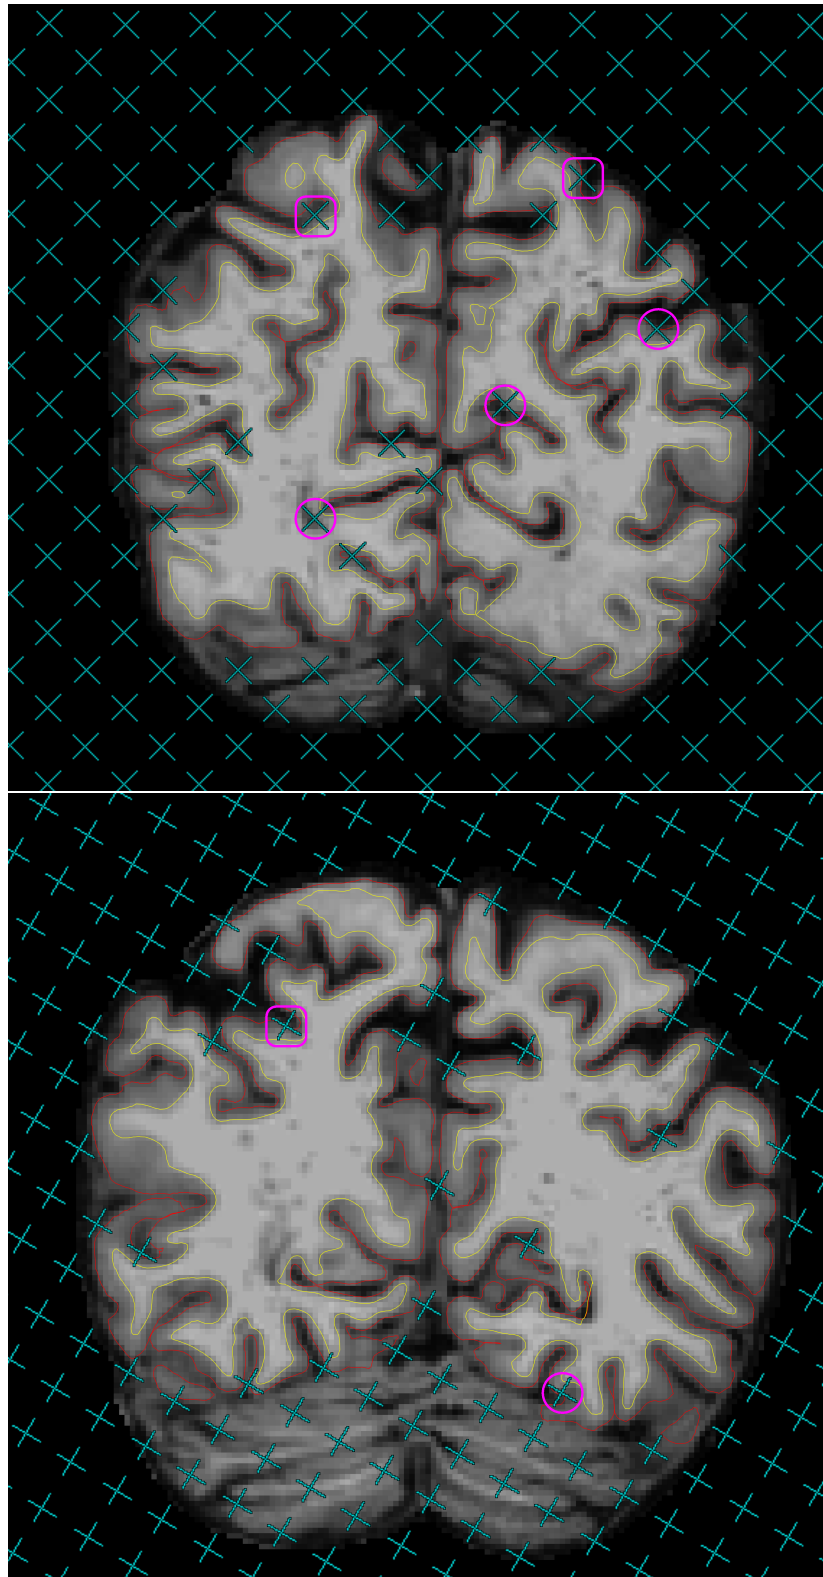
On the 4th and 5th slices of one brain MR image in the coronal view, uncounted test points (cyan) which miss the cerebral parenchyma or hit the ventricles are overlaid onto pial profiles (red lines) segmented by FREESURFER. Circles (pink) mark the uncounted test points which fall inside the grey matter boundaries (red lines) and rounded rectangles (pink, racetrack-like) mark the test points hitting exactly on the grey matter boundaries.
